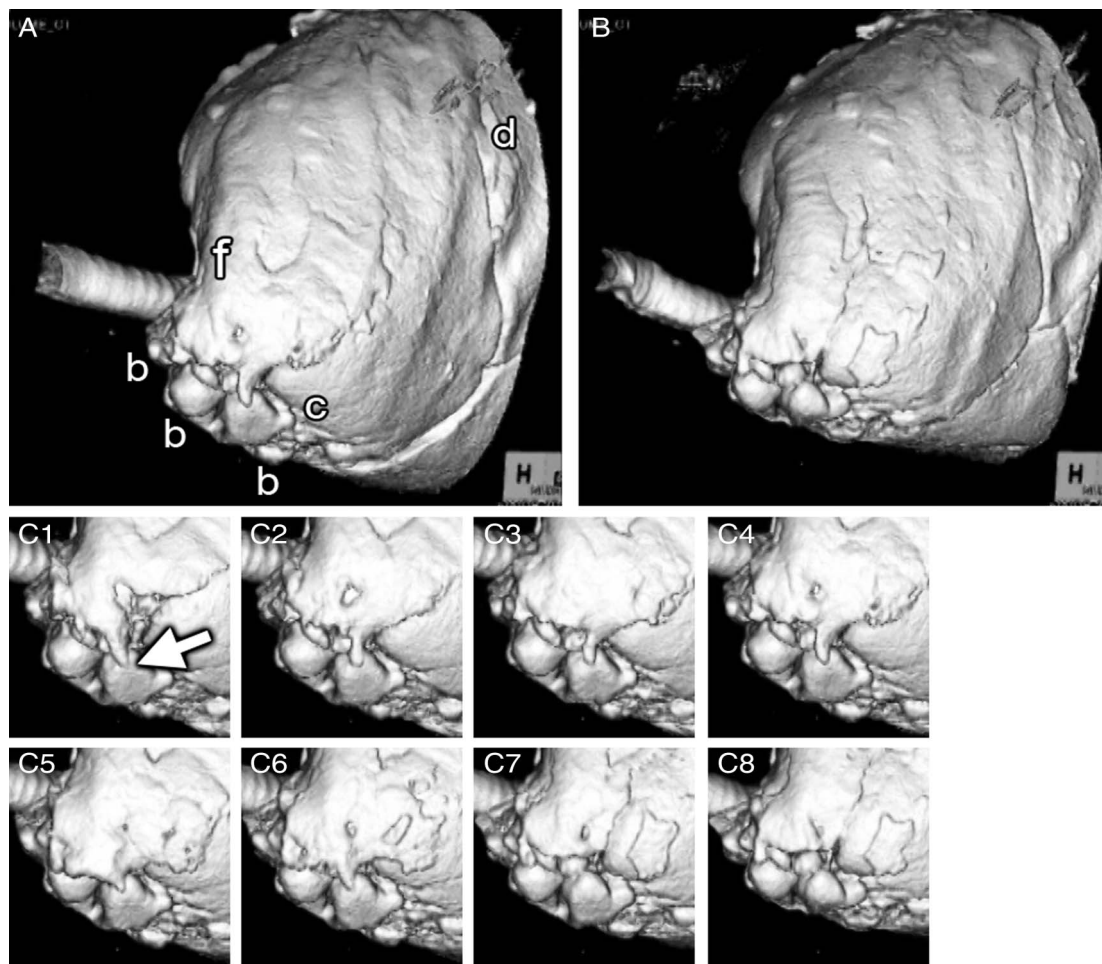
Motion of air on four-dimensional CT thoracographic images (case 1). (A) Maximum inspiratory time: (b) bullous lesions; (c) causative lesion of the air leak; (d) preplaced drain; (f) free pleural space of pneumothorax. (B) Maximum expiratory time. Only surfaces of air are rendered within the upper half of the right thoracic cage. The aerial areas are the airway from the trachea to the alveoli, bullous lesions, pneumothorax space and leaked air. Leaked air is shown only in (A). (C1–8) Sequential images. An aerial train connecting a bulla to a space of pneumothorax that appeared during inspiration (C1). The train spread along the lung and enlarged the pleural space (C2–C5). After changing to expiration, the funnel-shaped part of the aerial train close to the bulla disappeared. According to the expiration, the train is divided (C5–8) and the pleural space is finally shrunk. This means airflow spouting from a bulla. The leak point can be judged to be where the tip of the funnel shape of the aerial train has appeared (C1, arrow).
